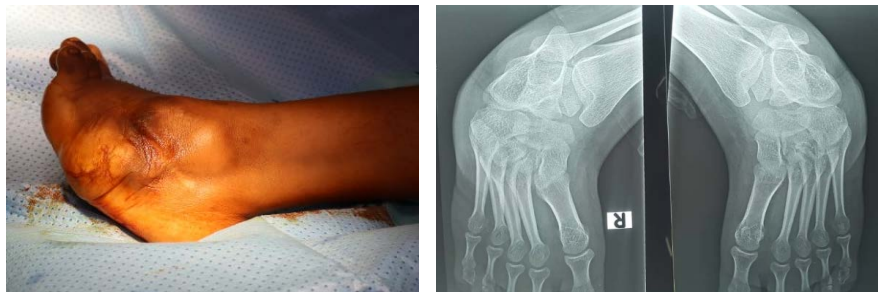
Show pre-operative clinical photo and X-ray.
